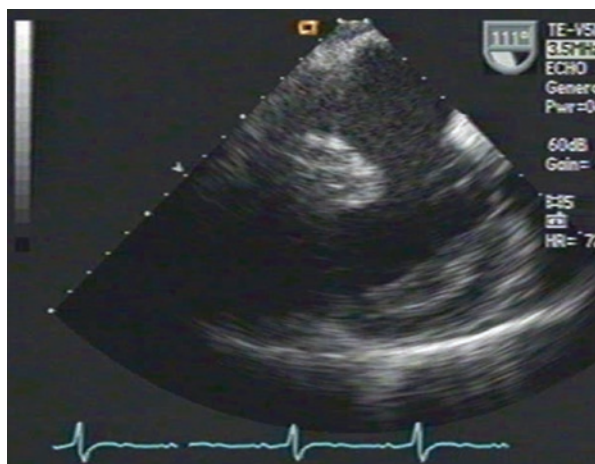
Short-axis view from transesophageal echocardiogram depicting a large pseudoaneurysm (higher cavity). Notice the narrow “shelf-like” opening into the aneurysmal cavity
